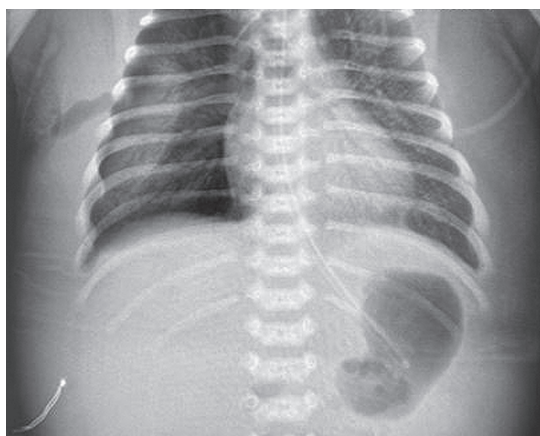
Chest X-ray of newborn on the ninth day of life
